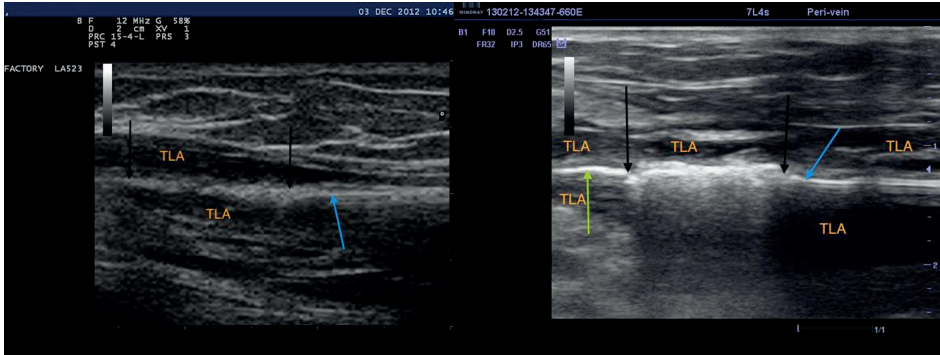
(Left) Ultrasound image of the central Great Saphenous Vein (GSV), about 8 s after starting EVLA at 810 nm. Blue arrow indicates the fiber tip. Part of the GSV between the black arrows just has been treated. TLA is the tumescent local anesthesia surrounding the GSV. Note that, compared to 1470 nm EVLA, lesser echogenicity of the GSV remnant. (Right) Ultrasound image of the central GSV, just 10 seconds after starting EVLA at 1470 nm. The segment of about 1 cm between the black arrows was treated; the fiber tip is at the point of the blue arrow. Left of the left black arrow, marked by a green arrow, a white line with a diameter of about 1 mm is visible, presumably caused by steam bubbles escaping into the common femoral vein. The untreated vein wall is visible around the fiber tip as grey lines, the treated vein wall as a linear and irregular but markedly echogenic structure.
